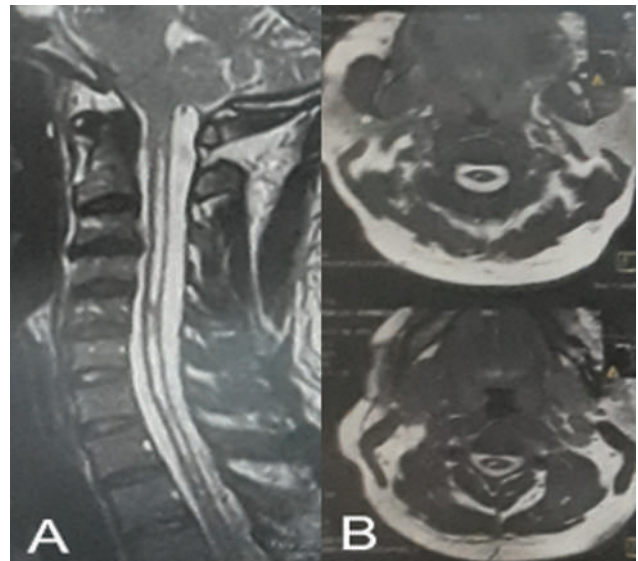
Cervical spine magnetic resonance imaging in T2-weighted sequence, in sagittal (A) and axial (B) sections, showing extensive hydrosyringomyelia at the C1-to-T2 level.
